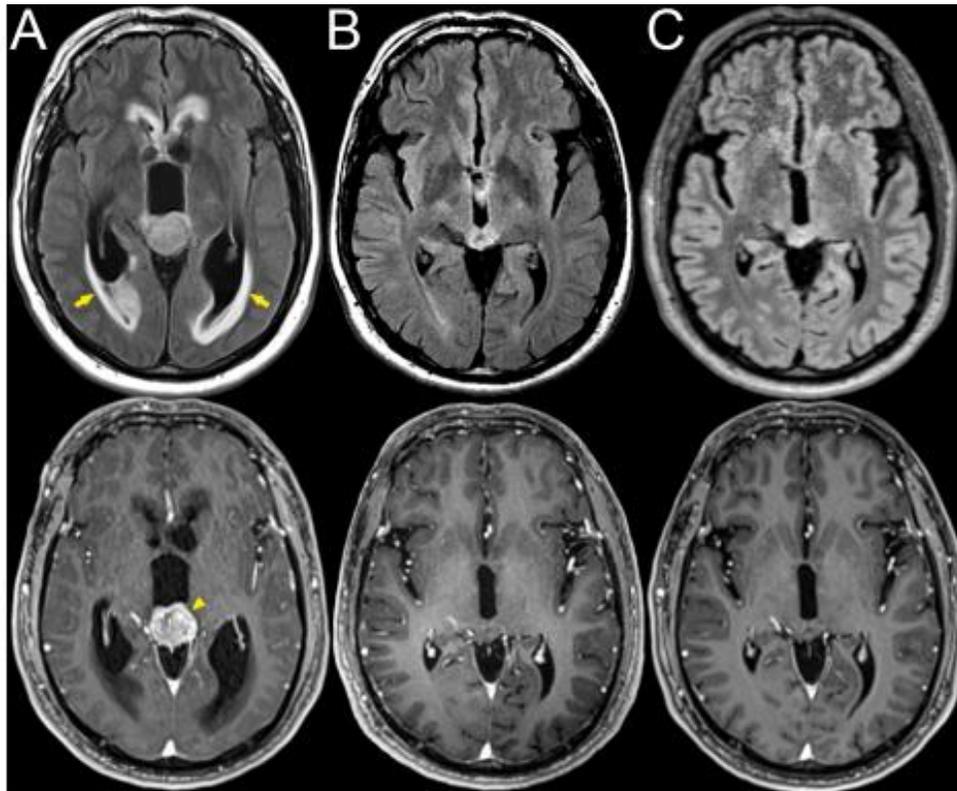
Axial T2/FLAIR weighted (top row) and T1-weighted post-contrast (bottom row) MR images at the level of the pineal region from the date of original diagnosis (A), at 1 year post-treatment (B), and 2.5 years post-treatment (C). Images at the time of diagnosis (A) show a heterogeneously enhancing pineal region mass (arrowhead) and associated triventricular obstructive hydrocephalus with periventricular edema (arrows). Post-treatment images (B and C) show decreased size of the pineal region mass with resolution of enhancement and associated hydrocephalus.
